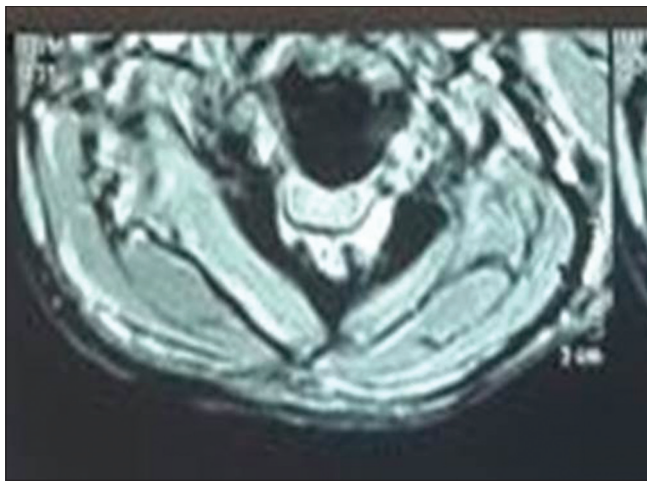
Cervical magnetic resonance imaging (axial view).
